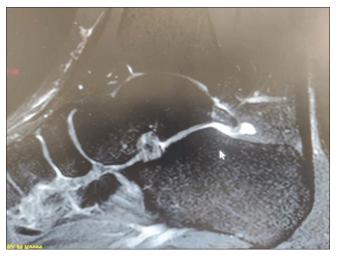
Magnetic resonance imaging image showing Stieda's process fracture
